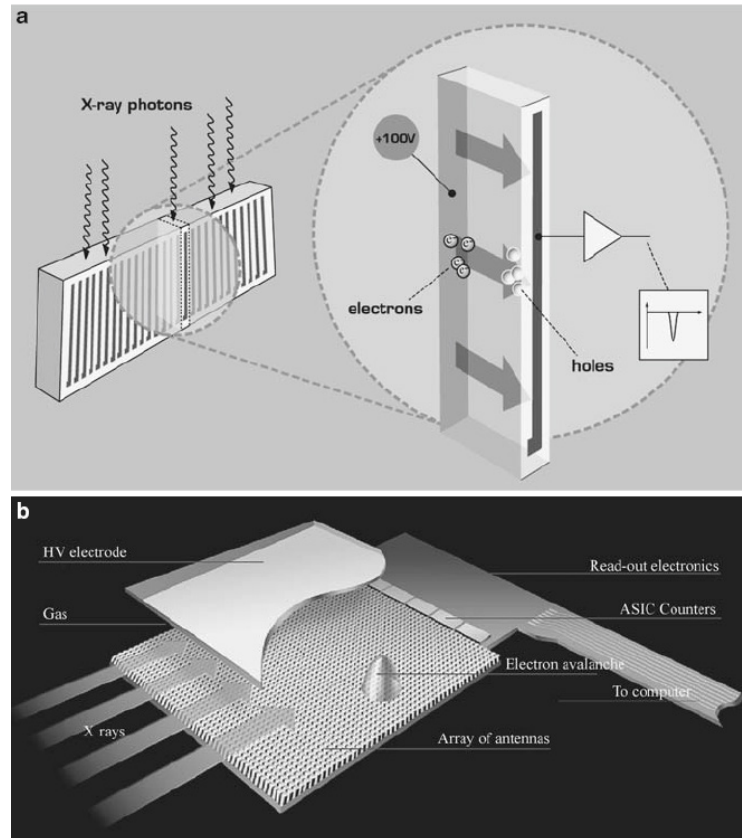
(a) X-ray counting detector based on silicon (photo courtesy SECTRA), (b) high pressure gas ionization detector (XCounter [30]).
